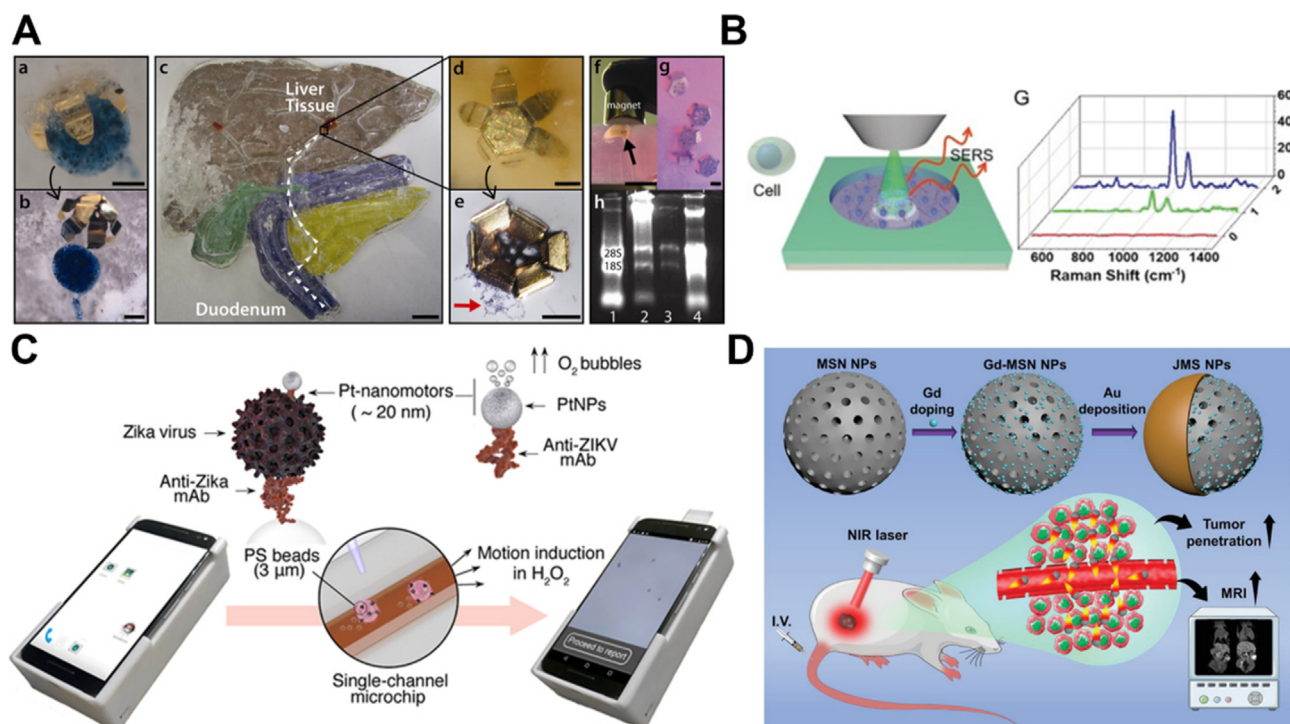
MNMs for diagnosis. (A) MNMs for external biopsy in a liver tissue from a model organ system, and RNA retrieval from captured cells. Reprinted with the permission from Ref. 188. Copyright © 2010 American Chemical Society; (B) capture of biological Raman signals of the cancer cells using photocatalytically powered match-like nanomotors. Reprinted with the permission from Ref. 131. Copyright © 2018 Wiley–VCH; (C) the detection of Zika virus by the change in the velocity of Pt-nanomotors. Reprinted with the permission from Ref. 195. Copyright © 2018 American Chemical Society; (D) MNMs as active diagnostic imaging agents for enhanced magnetic resonance imaging of tumor tissues. Reprinted with the permission from Ref. 196. Copyright © 2021 Wiley–VCH.
